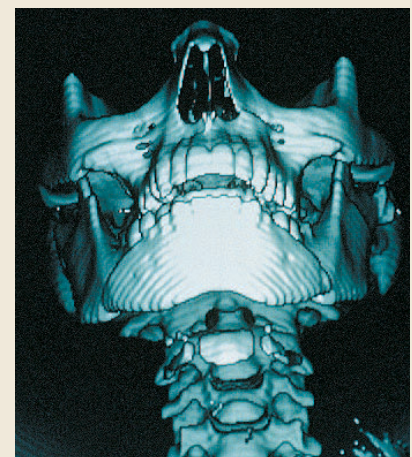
Figure D Computed Tomography (CT)
